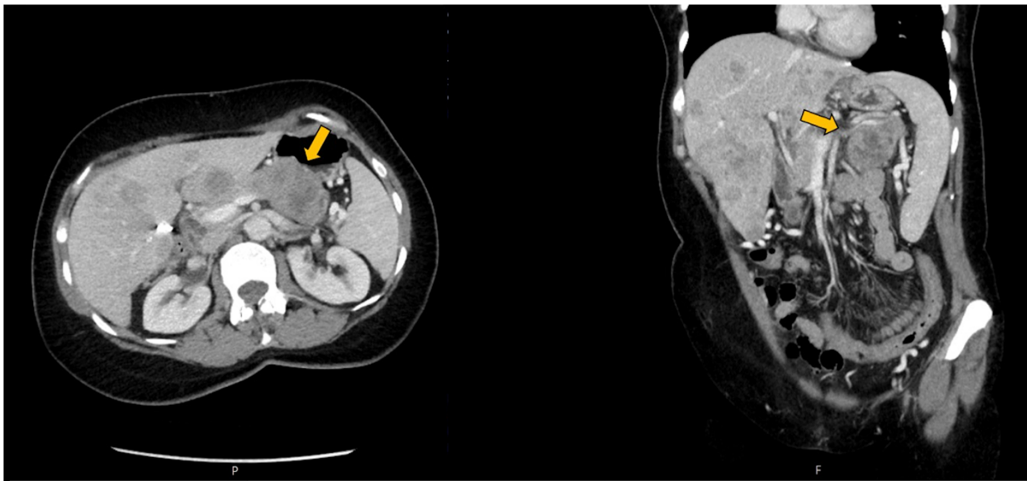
CT at presentation (September 2018) demonstrating the primary tumour in the pancreatic body (yellow arrow).
